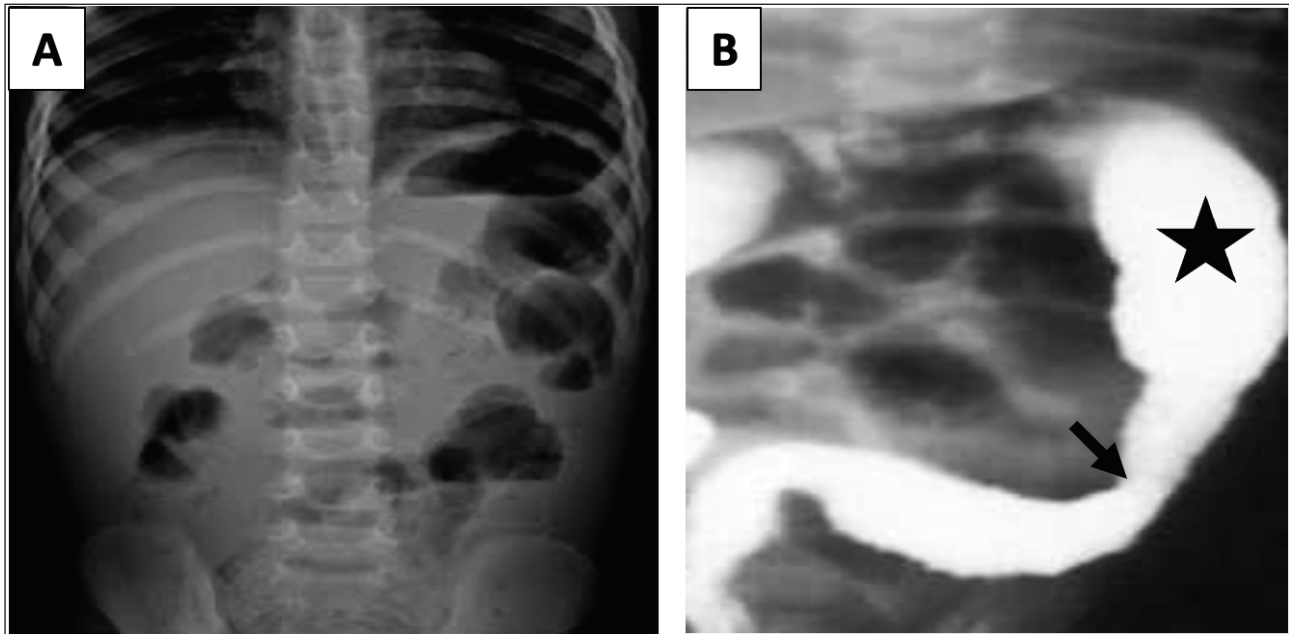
(A) Plain abdominal radiograph demonstrates grossly dilated bowel loops with multiple air-fluid levels, highly suggestive of distal intestinal obstruction. Contrast (barium) enema outlines a rectosigmoid transition zone (black arrow) with markedly dilated proximal bowel (black star).
